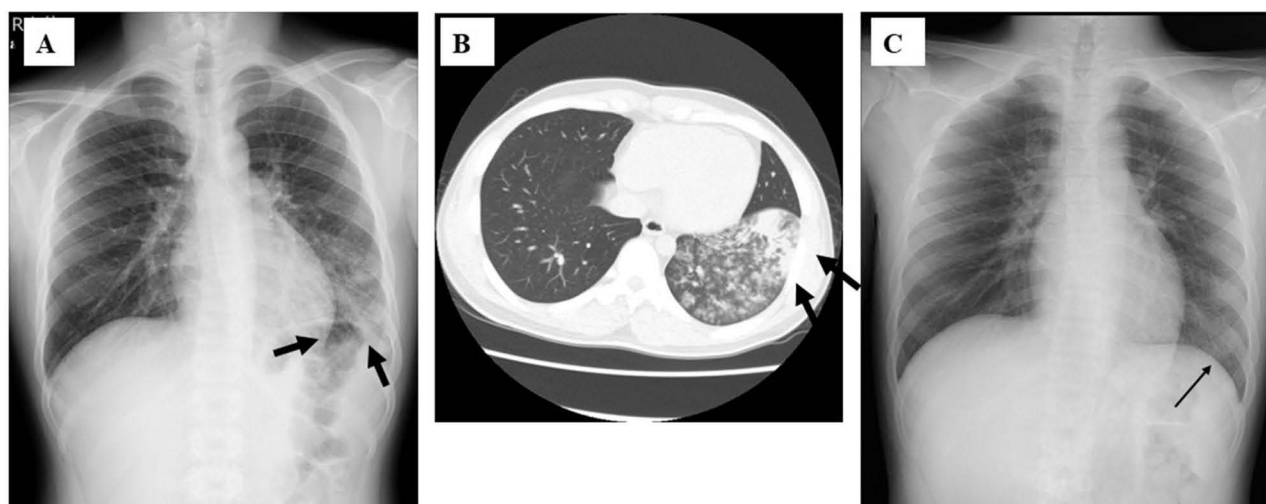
Chest X-rays (A and C) and computed tomography (B) of the Case 1 patient. At admission, there are abnormal shadows on the chest X-ray (A) and computed tomography (B), but these shadows improve after treatment (C). Arrows indicate the abnormal shadows.
